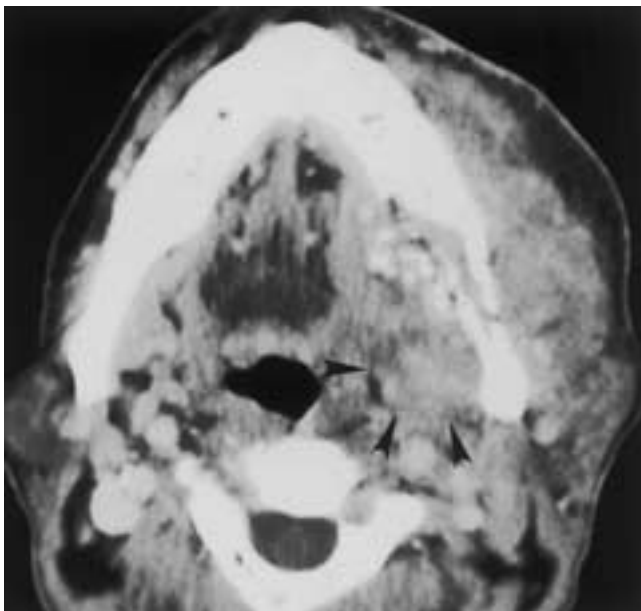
Squamous cell carcinoma of the buccal mucosa. Axial contrast-enhanced CT scan demonstrates a large mass on the left, with its epicenter located in the left gingiva-buccal mucosa. There is obvious destruction of the posterior aspect of the left mandible. Medial to the mandible, the tumor appears to be extending along the mylohyoid muscle to involve the deep aspect of the submandibular space (*arrowheads*).
